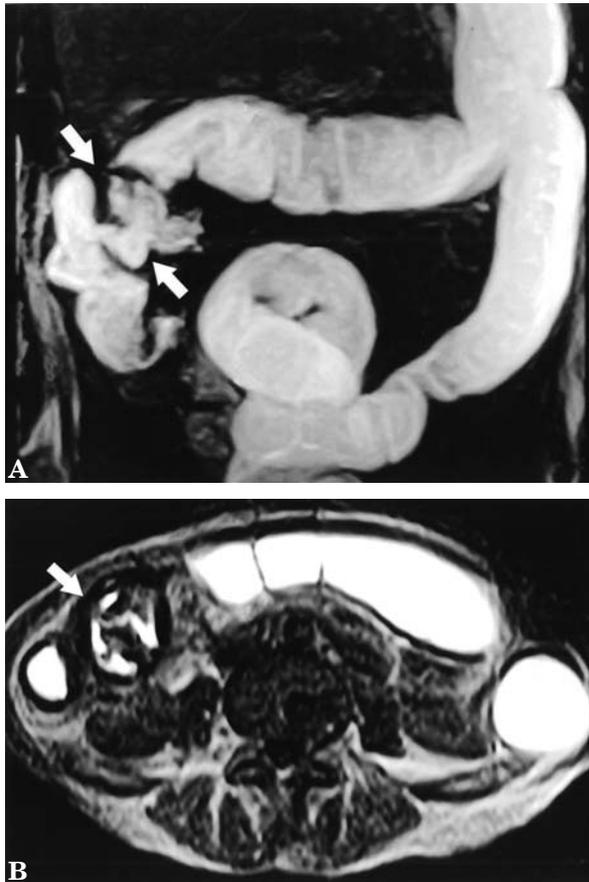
A 59-year-old woman with cecum and ascending colon carcinoma. A) MR colonography MIP image shows asymmetrical, irregular wall thickening at the cecum and ascending colon segments (arrows). B) T1-weighted axial plane image shows asymmetrical wall thickening at the cecum (arrow)
